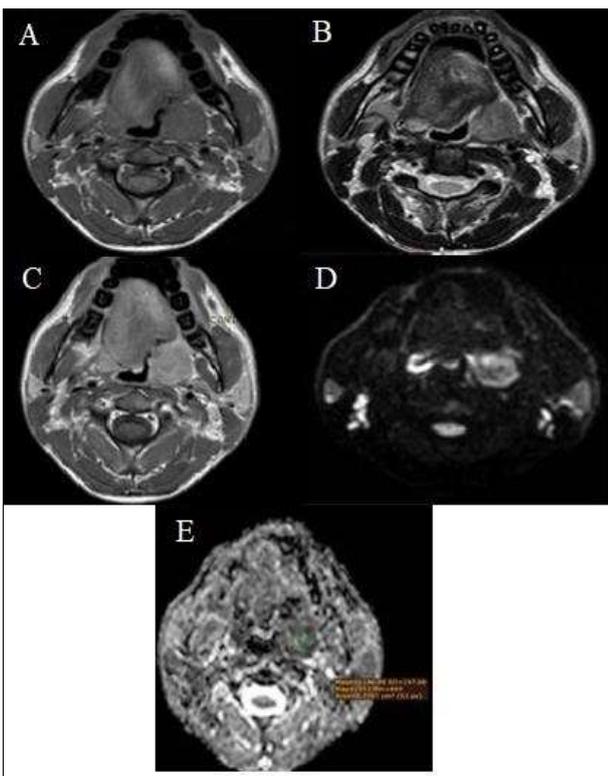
MRI findings: (A) Mass at left Para pharyngeal space that appears low signal intensity at T₁WI, (B) intermediate signal intensity at T₂WI, (C) with homogeneous enhancement at T₁WI with contrast, (D) seen restricted on DWI, (E) with ADC value estimated to be $1.146 \times 10^{-3} \text{ mm}^2/\text{s}$ MR diagnosis: recurrent mucoepidermoid carcinoma
